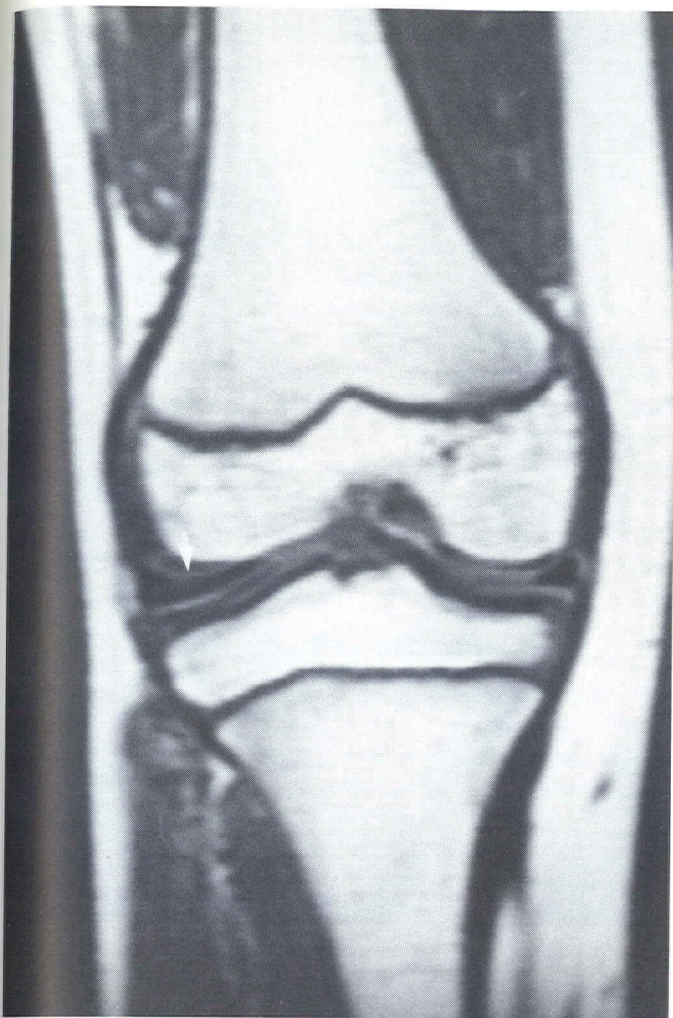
High-speed three-dimensional acquisition MR image of the knee (gradient recalled echo in the steady state) noticed persistent low signal of normal-appearing meniscus. Articular hyaline cartilage is of high signal intensity with this pulse sequence facilitating its visualization.
